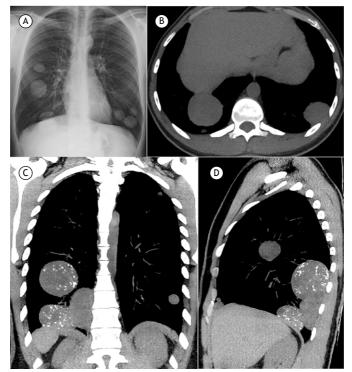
A chest radiograph (in A) and a chest CT scan (in B) obtained in October of 2017 showing multiple noncalcified nodules and masses in both lungs, predominantly in the lower regions. A chest CT performed two years later in the coronal (in C) and sagittal (in D) planes demonstrated growth of the nodules and masses, which contained calcification foci.
